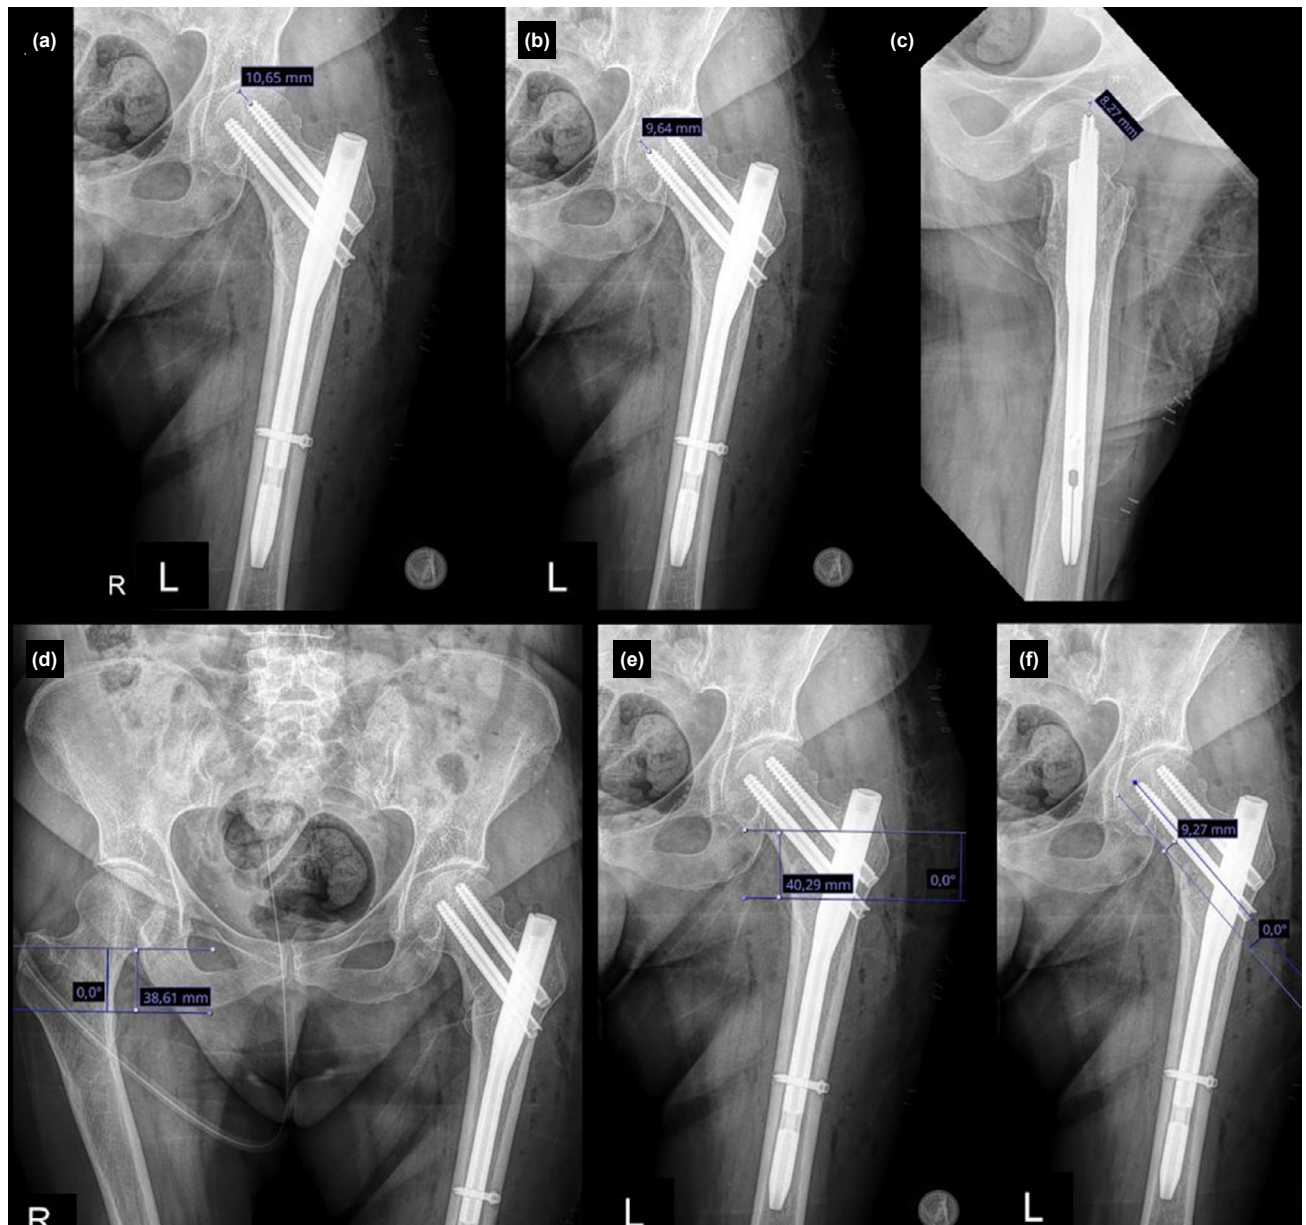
Radiographic measurements for the standard proximal femoral nail (PFN). (a) Anteroposterior proximal lag screw tip–head distance (ApLAG1); (b) Anteroposterior distal lag screw tip–head distance (ApLAG2); (c) Lateral tip–apex distance (LatTAD); (d) Normal-side trochanter minor–calcar distance; (e) Trochanter minor–calcar distance; (f) ApLAG2–calcar distance.
